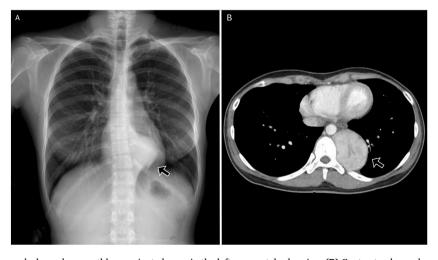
(A) Chest radiograph showed a smoothly marginated mass in the left paravertebral region. (B) Contrast-enhanced computed tomography of the chest demonstrated a lobulated mass with a size of 5.8cm in greatest diameter and heterogeneous enhancement located in the left posterior mediastinum.
